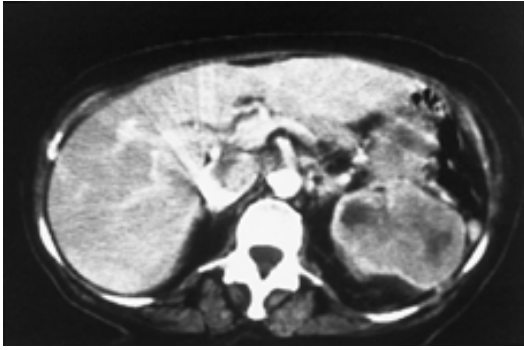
Axial view of computed tomography scan demonstrating large left renal mass. Also note contrast-filling defect in vena cava from associated tumor thrombus.
